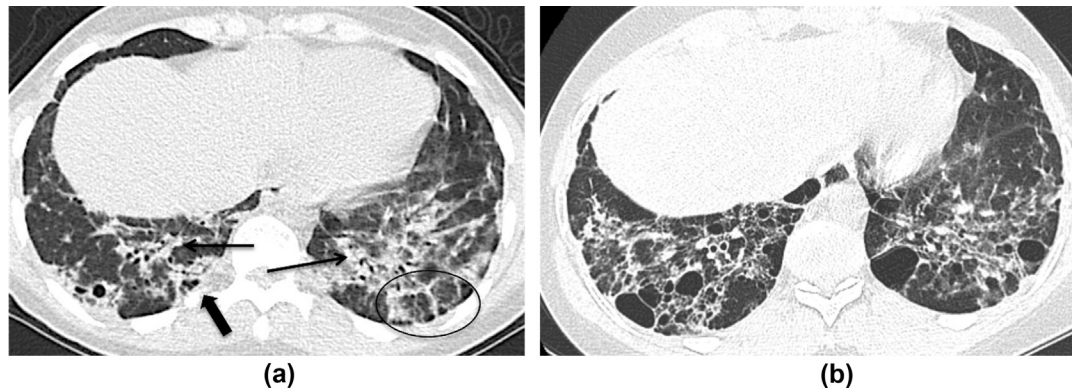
Fibrotic OP pattern in a patient with dermatomyositis. (a) Initial CT demonstrates patchy consolidations with peribronchial (thin arrows) and subpleural (thick arrow) distribution, in addition to subpleural peribulbar opacities (circle). (b) CT 4 years later shows the fibrotic evolution of OP. Imaging findings in OP are highly variable, with the most common features being patchy subpleural, peribronchial, or band-like consolidations. The presence of migratory consolidation (Electronic [Supplementary Material Fig. S5](#)), peribulbar opacities or reverse halo sign increases the diagnostic confidence.
